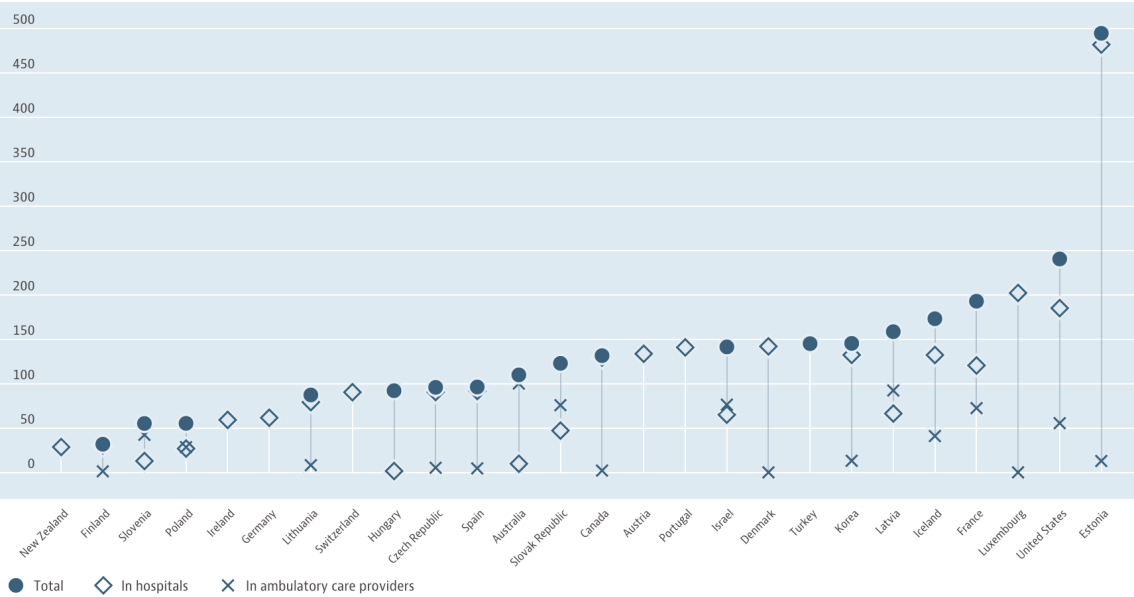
CT Scans per 1000 inhabitants OECD Health Data.
